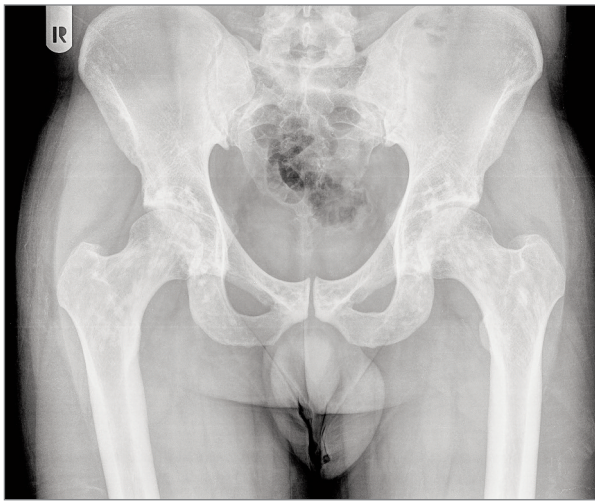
Pelvis AP radiography (case 3)
